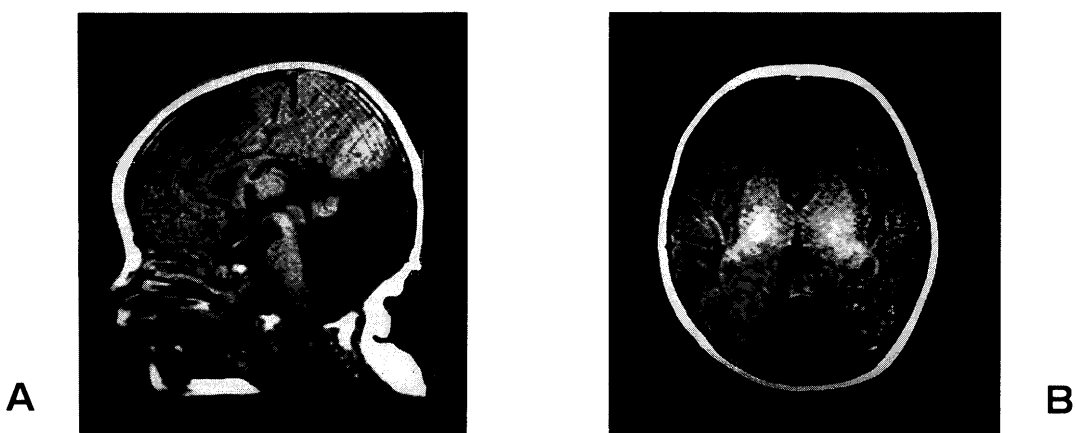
T1 weighted image (TR 400msec, TE 14msec) of 1.5 Tesla MRI on 50 days after birth. A, Sagittal images. Cystic dilatation of the fourth ventricle, elevation of the tentorium and thickness of the corpus callosum were noted. The rudimentary incomplete vermis now becomes recognizable. B, Axial images. No enlargement of the lateral ventricles nor migration disorders of the cerebral cortex were noted.
